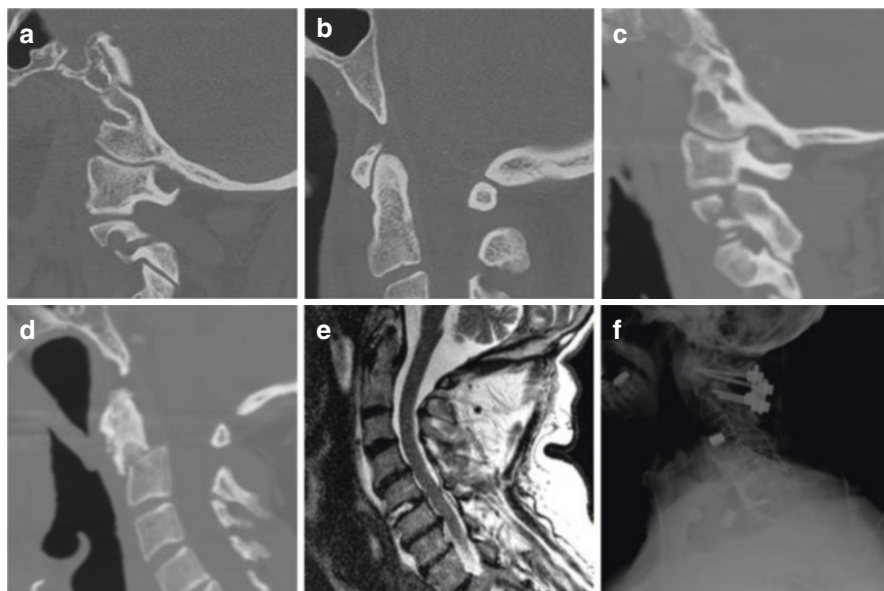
(a, b) Sagittal cervical CT showing Effendi type I fracture with a nondisplaced pars fracture without displacement of C2 on C3 vertebral bodies. Images (c–f) belong to the same patient. (c) Sagittal CT angiogram of the neck showing a fracture through the pars interarticularis of the atlas. (d) The same patient had a concurrent odontoid fracture with associated angulation of the posterior aspect of the C2 odontoid on the remaining C2 and C3 vertebral bodies. (e) T2 sagittal cervical spine MRI showing an associated rupture of the C5–6 intervertebral disc. (f) The patient underwent a staged C5–6 ACDF followed by a posterior C1–2 fusion
